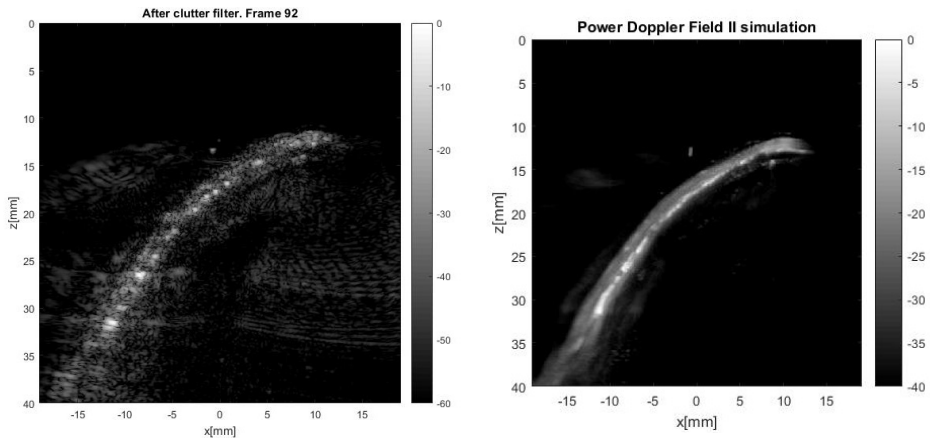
6c show the acquired signal before and after clutter filtering, respectively. Before cluttering filtering only tissue is visualized in the B-mode image. The spectra in Figure 4.6b show that the clutter component, still centered at $v=0$ m/s is completely removed after filtering. Only the blood signal is displayed in the filtered B-mode image in Figure 4.6c. The blood flow can be visualized by the power Doppler image in Figure 4.6d.
